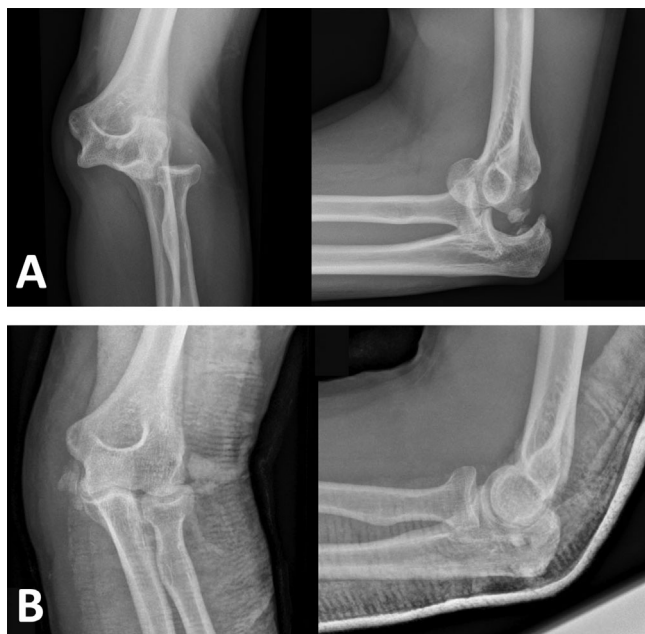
(A) Anteroposterior and lateral x-rays of the left elbow showing posterior dislocation of the joint with adjacent bony fragment. (B) Postreduction satisfactory alignment of the bones with joint immobilization in a back slab
